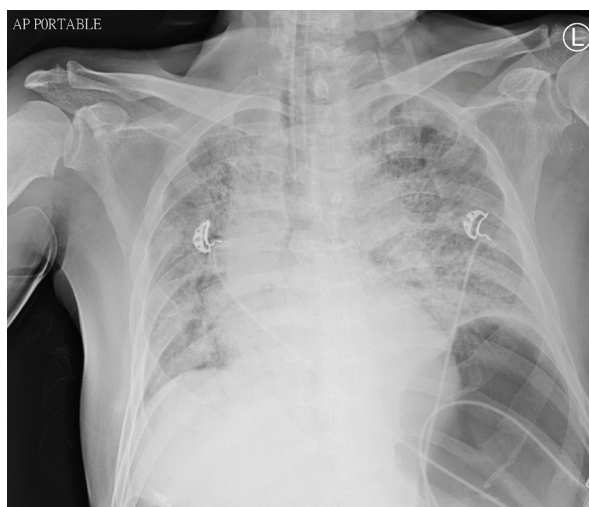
Chest radiograph anterior-posterior view taken on March 10th, 2020, the day the patient was intubated.
